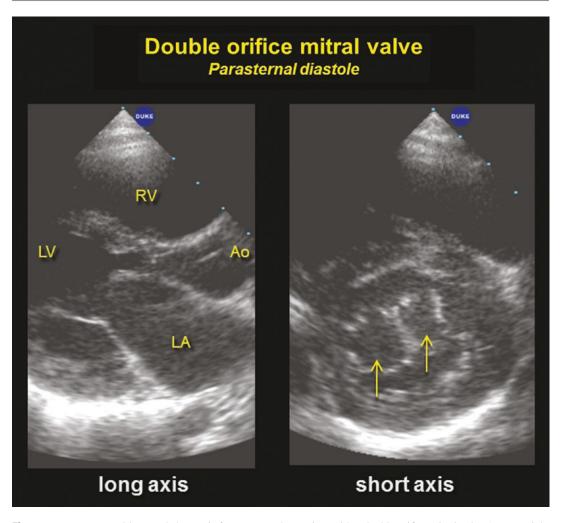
Parasternal long and short axis from yet another patient with a double orifice mitral valve (arrows, right panel)
